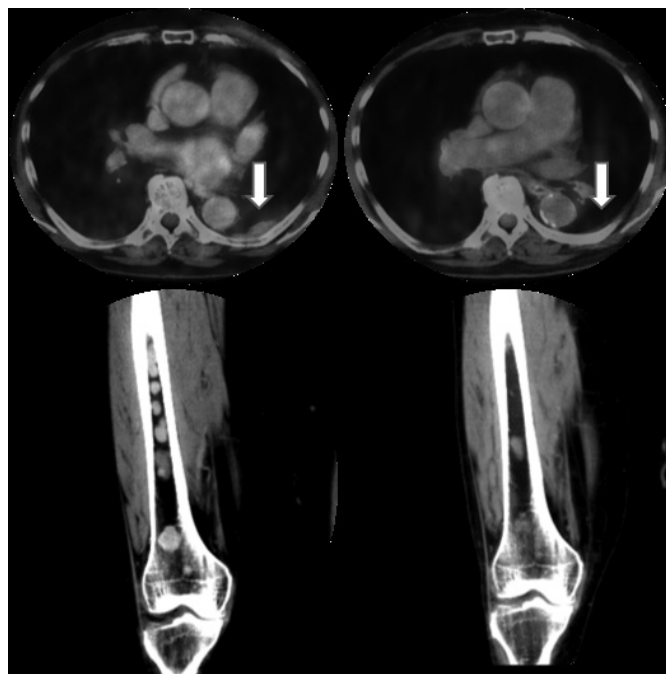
PET and CT reconstructions of EMD and bone marrow infiltration after MOR202 and DARA
